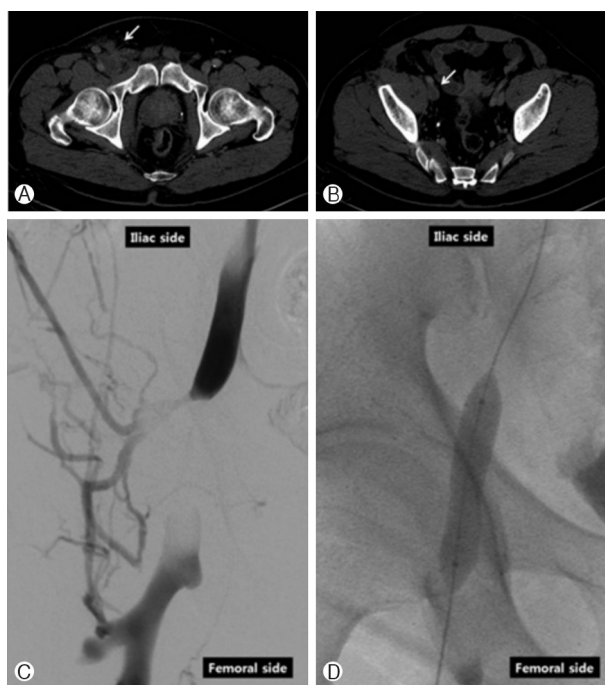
CT and venography with balloon dilatation before the hematoma evacuation. (A) Hematoma as a low-density lesion in the right inguinal area (arrow). (B) Venous thrombosis in the right external iliac vein (arrow). (C) Complete obstruction of the common femoral vein due to external compression. (D) 10-mm balloon dilatation which inflated easily, but immediately recoiled.
